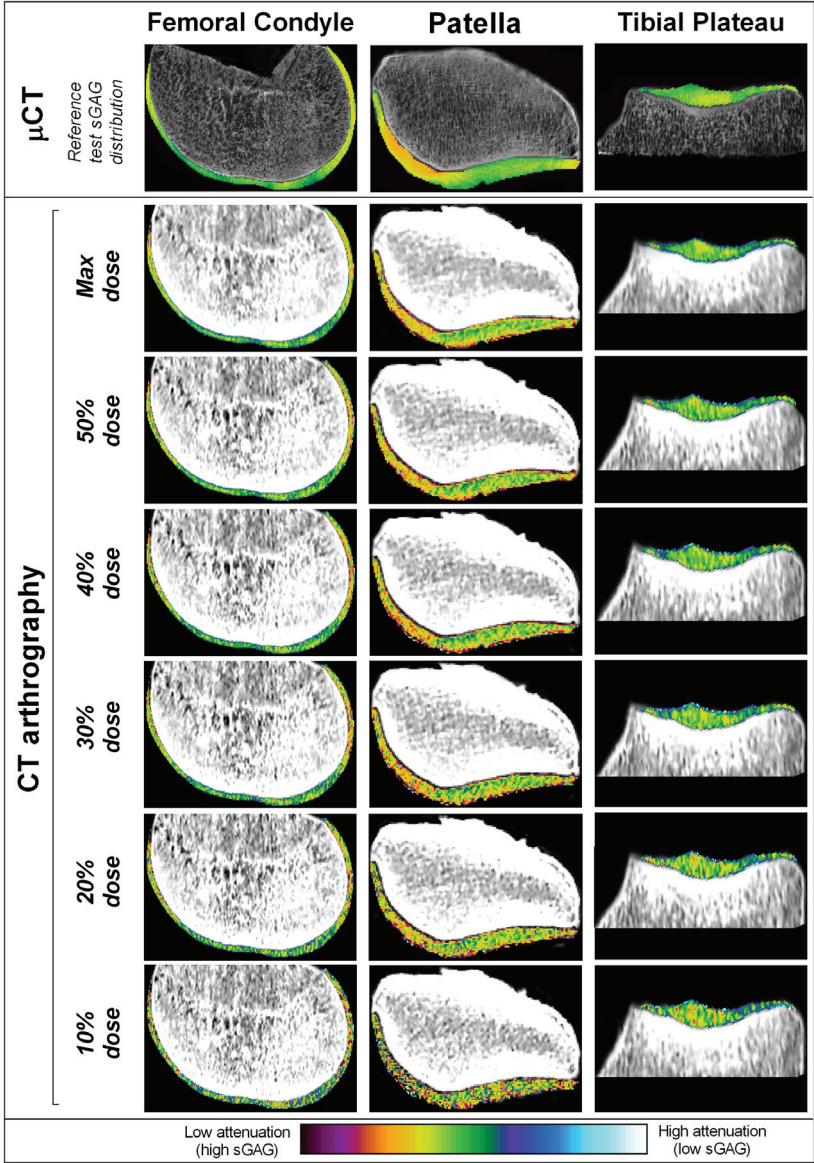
Registered images of both EPIC- μ CT and CT arthrography acquired using different radiation doses (maximum radiation dose, 50%, 40%, 30%, 20% and 10% of the maximum radiation dose) per scan. The attenuation of cartilage regions is visualized in color and representative for the sGAG content of the cartilage. High attenuation values represent low sGAG content and low attenuation values represent high sGAG content.
